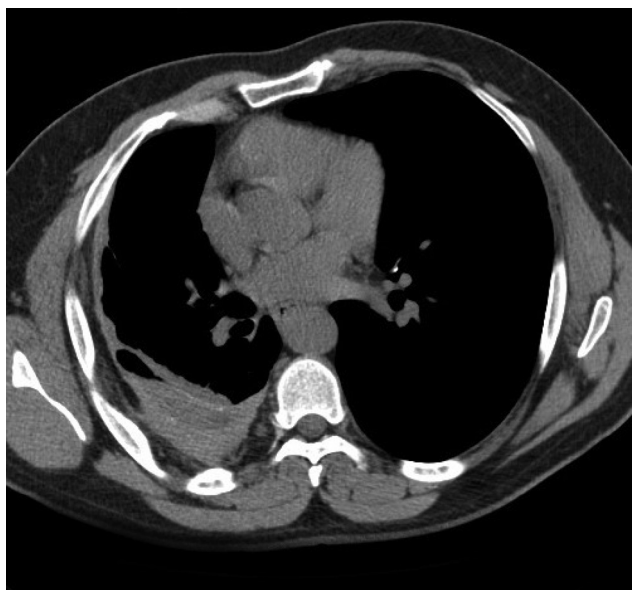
Computed tomography scan showing a right hemothorax and an expansive lesion affecting the lower lobe of the right lung.
